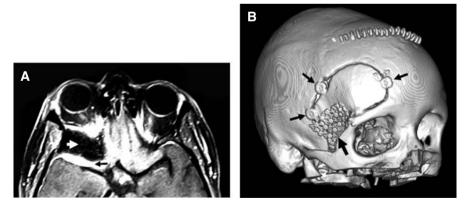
A T1-weighted Gd-enhanced MR image of a spheno-orbital or en plaque meningioma. Note extensive bony hyperostosis (white arrow) and the enhanced plaque of the lesion (black arrow). B 3-D reconstruction of the craniotomy site showing closure using the Craniofix titanium clip (3 small arrows) (CF: Aesculap AG, Tuttlingen, Germany) and titanium mesh (large arrow)
